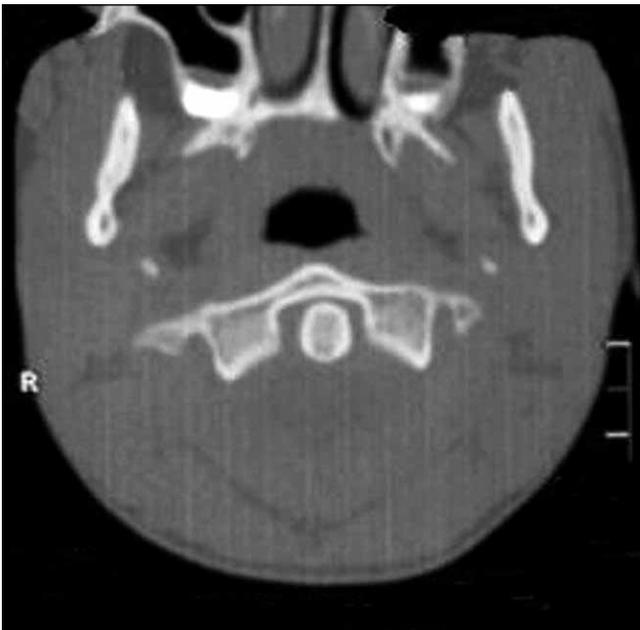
Axial CT scan showing the recovery of atlanto-axial subluxation.
